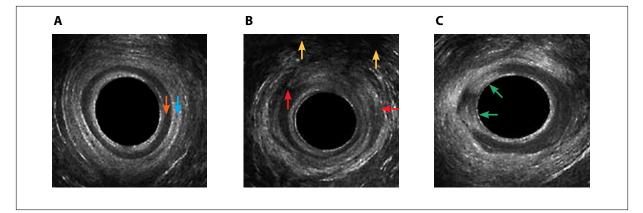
Anal endosonography images. A shows a healthy individual with a hypoechoic internal anal sphincter (orange arrow) and mixed hypo- and hyperechoic external anal sphincter (blue arrow). B shows an FI patient with both internal and external anal sphincter defects (between the red arrows) and hemicircumferential anal sphincteroplasty (between the yellow arrows). C shows an FI patient with lateral anal sphincterotomies (green arrows).
